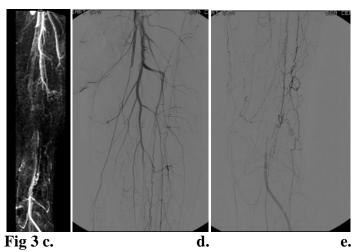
The doppler ultrasound images for the left thigh region show normal triphasic waves in the proximal SFA (Fig 3 a) and complete occlusion of the left distal SFA (Fig 3 b). The corresponding CEMRA (Fig 3 c) and DSA (Fig 3 d and e) also show the same findings. Also noted is reformation of the distal SFA from collateral vessels arising from the left DFA.
